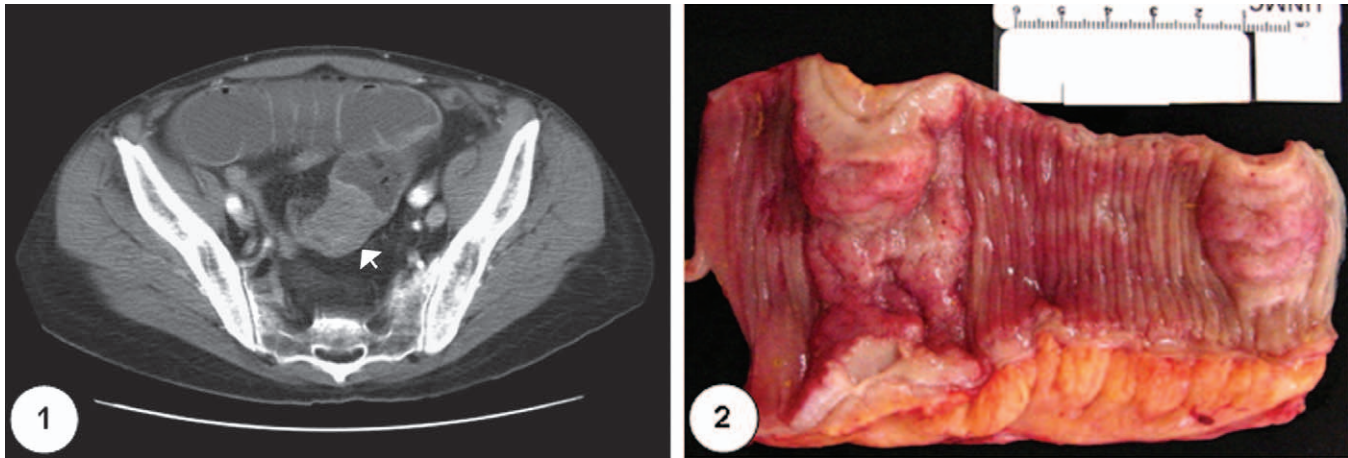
Abdominal computed tomographic scan showing a 4-cm region of circumferential thickening involving the ileum (arrow). The patient is a 55-year-old man with a past medical history of acute myeloid leukemia M2 in complete remission diagnosed 2 years earlier and was status post allogeneic peripheral stem cell transplantation.
